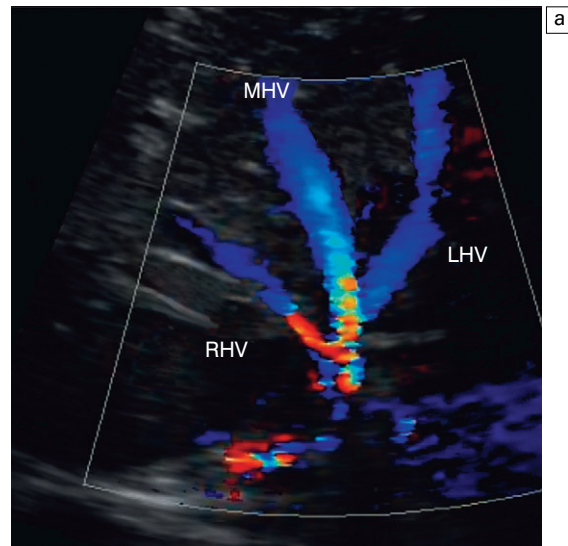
(a) Colour Doppler transverse view of the liver with a subcostal approach. This colour crow's foot appearance of the three hepatic veins confirms their patency. The direction of flow is away from the transducer and towards the heart. Right, middle and left hepatic vein, RHV, MHV, LHV. (b) Power Doppler image in this patient shows the convergence of five hepatic veins (HV's). The presence of accessory branches is very common.
